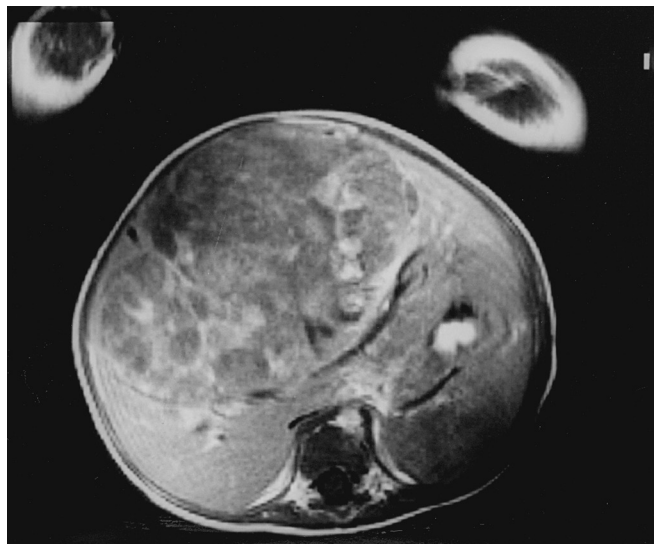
Computed tomogram of a hepatoblastoma in an 8-month-old girl. The child presented with hepatomegaly, increased abdominal girth, weight loss, and lethargy. The voluminous tumor occupies a large part of the upper abdominal cavity.
